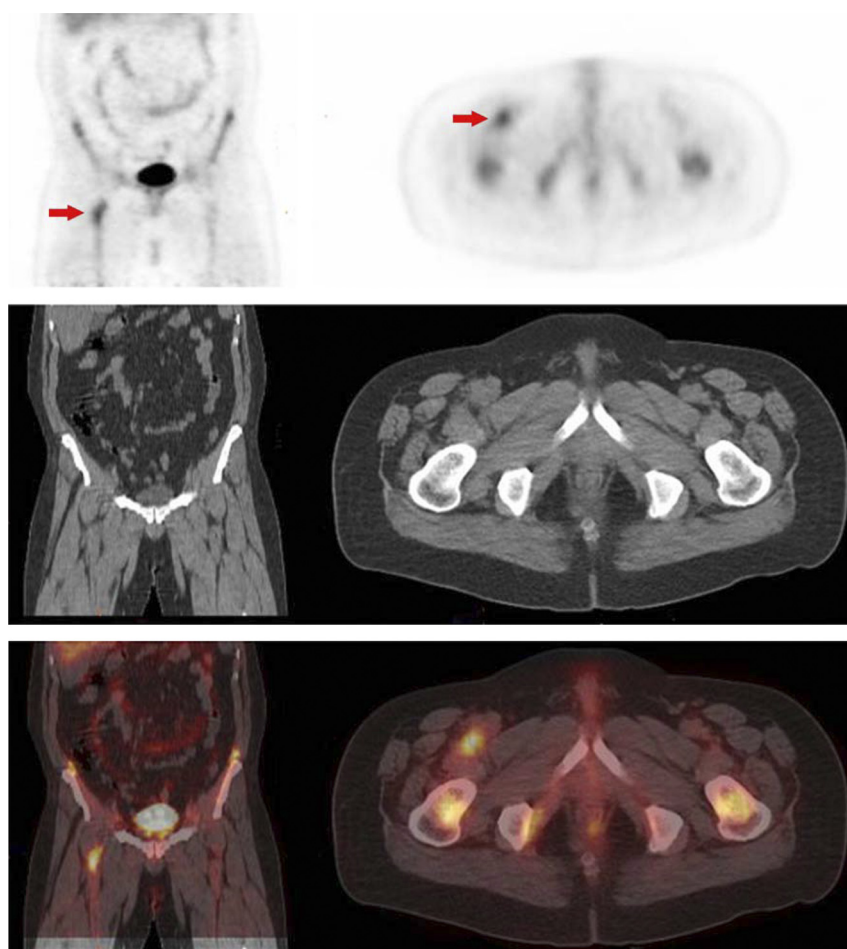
Mycotic aneurysm of the a. femoralis profunda in a 49-year-old man with *Staphylococcus aureus* bacteremia and endocarditis. Top to bottom, FDG-PET, CT, and fusion; left, coronal; right, transverse slices. FDG-PET/CT shows abnormal FDG uptake (arrows) compatible with vascular infection. [This figure can be viewed in color online at <http://www.md-journal.com>.]
